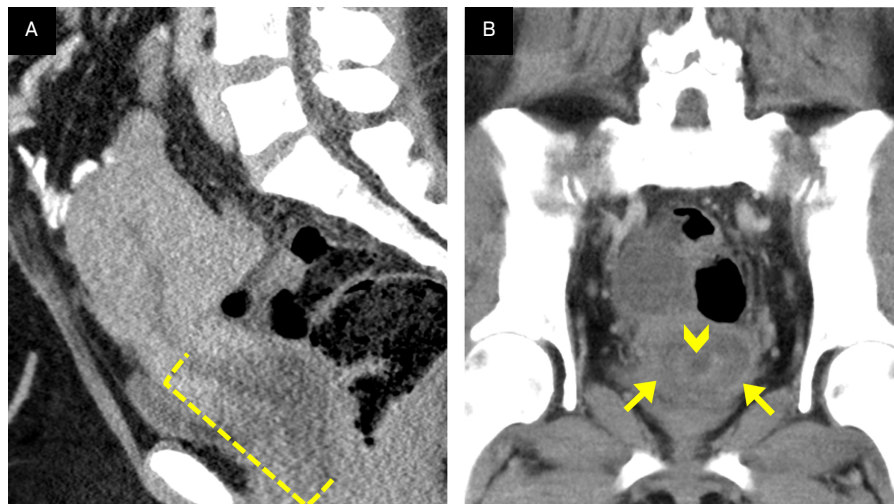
(A) Sagittal contrast-enhanced CT images demonstrate the low-density endocervical mass (bracket) with extension into the vaginal cavity. (B) Coronal images demonstrate the endocervical component of the mass (arrowhead) with surrounding dilated cervical tissue (arrows).
